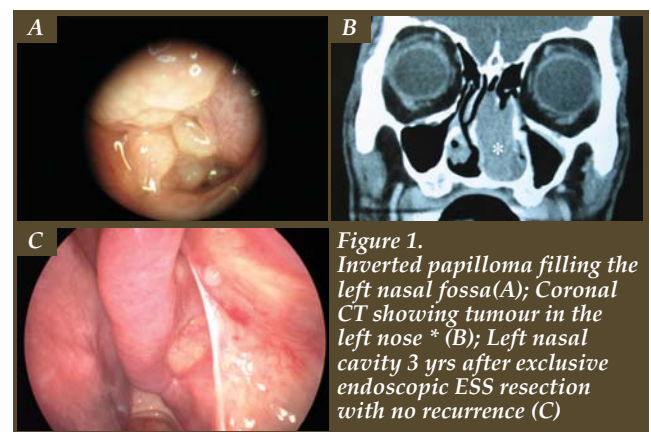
Inverted papilloma filling the left nasal fossa (A); Coronal CT showing tumour in the left nose \* (B); Left nasal cavity 3 yrs after exclusive endoscopic ESS resection with no recurrence (C)
